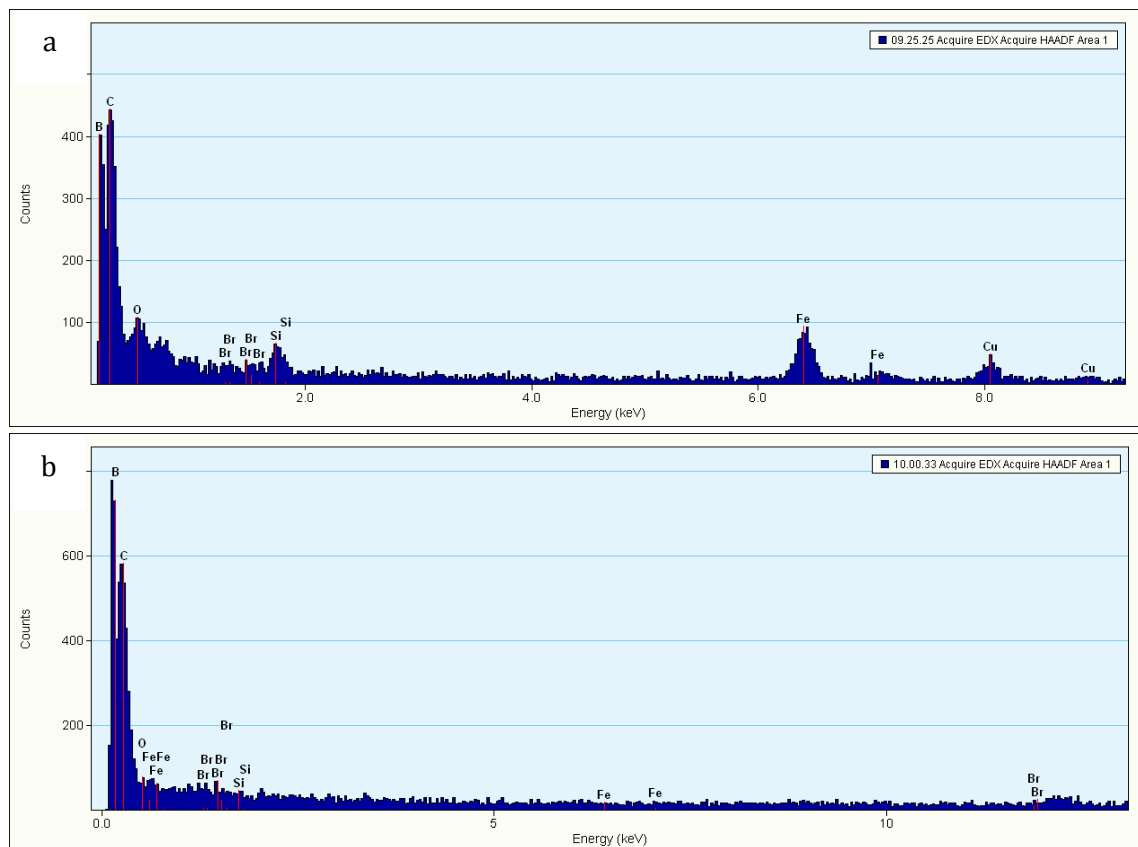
Energy Dispersive X-Ray analysis of BODIPY functionalized silica coated SPIONs (10).
